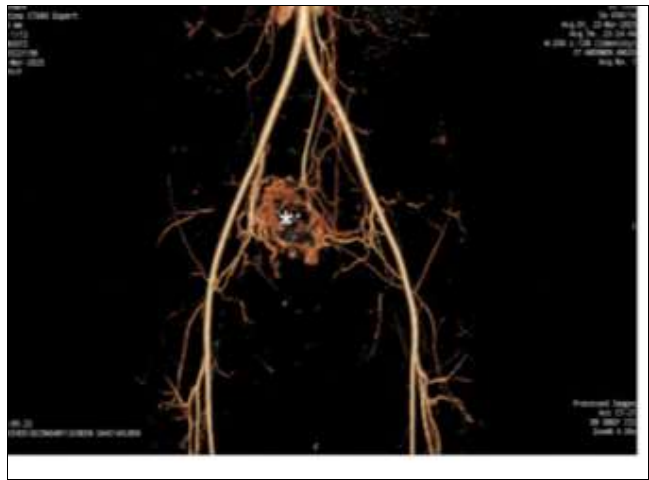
3D volume-rendered CT angiogram showing vascular anatomy and feeding vessels”
